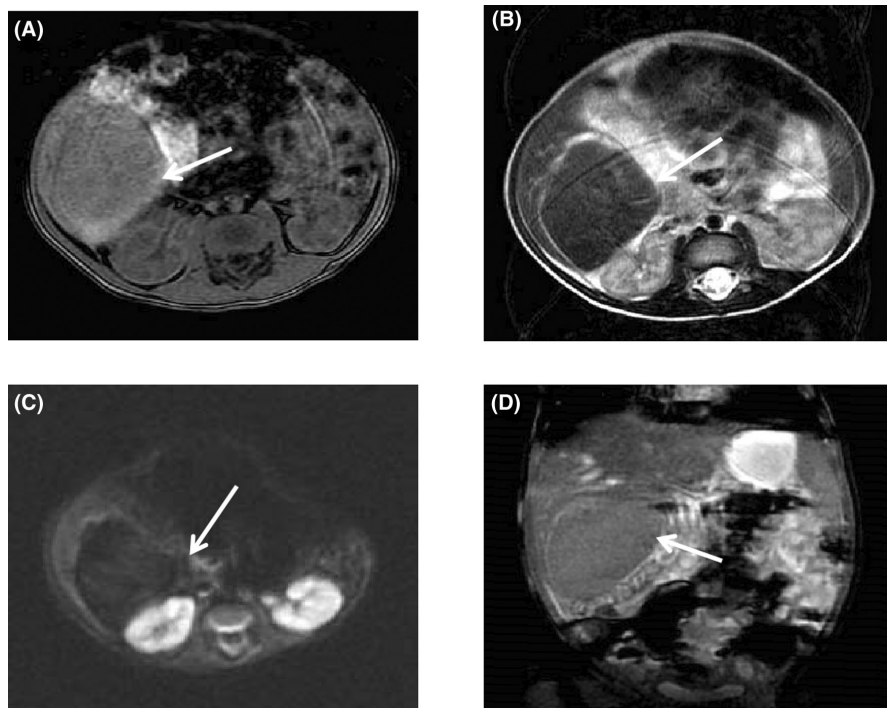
MRI on Day 4 shows the abdominal mass isointensity on (A) T1-weighted and hypointensity on (B) T2-weighted and (C) DWI in the hepatorenal space. (D) Coronal fat-suppressed T2-weighted showed no clear demarcation between the mass and the liver, and a cambered hyperintensity was found around the lesion on T2-weighted.
